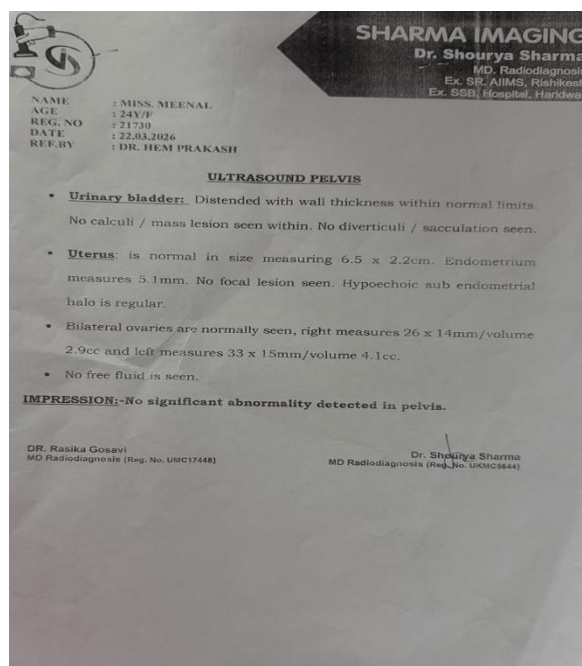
Ultrasonographic findings after treatment showing normal ovarian morphology. Ultrasonography reports revealed that uterus was normal in size and both ovaries were normal in size, shape and texture.
